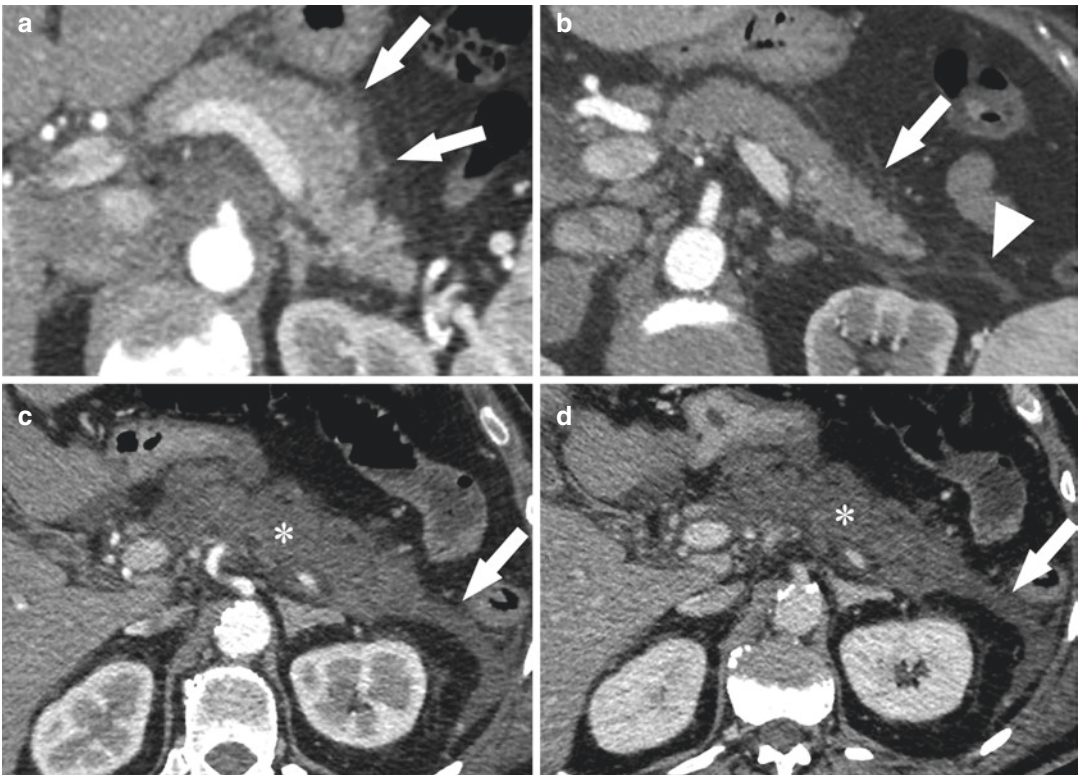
Acute pancreatitis. (a) IEP in a 27-year-old woman. Axial contrast enhanced pancreatic phase CT image shows irregular pancreatic contours and peripancreatic inflammation (arrows) with normal pancreatic enhancement and no collections. (b) IEP in a 63-year-old man. Axial contrast enhanced pancreatic phase CT image shows normal pancreatic enhancement with mild peripancreatic fat stranding (arrow) and a small amount of fluid in the left anterior pararenal space (arrowhead). (c, d)
